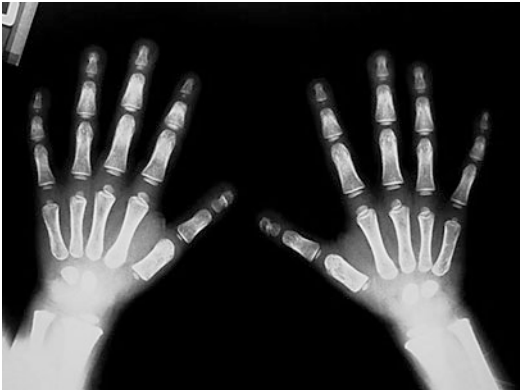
Hand radiograph at age of 4 years showing multiple sclerotic lesions along the axis of phalanges and metacarpals
